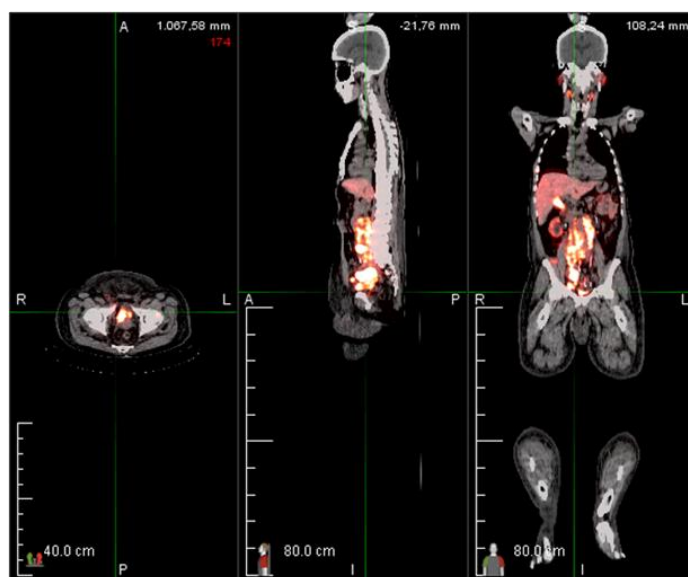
PSMA PET CT scan revealed increased uptake in the prostate, multiple lymphadenopathies, and multiple bone lesions
